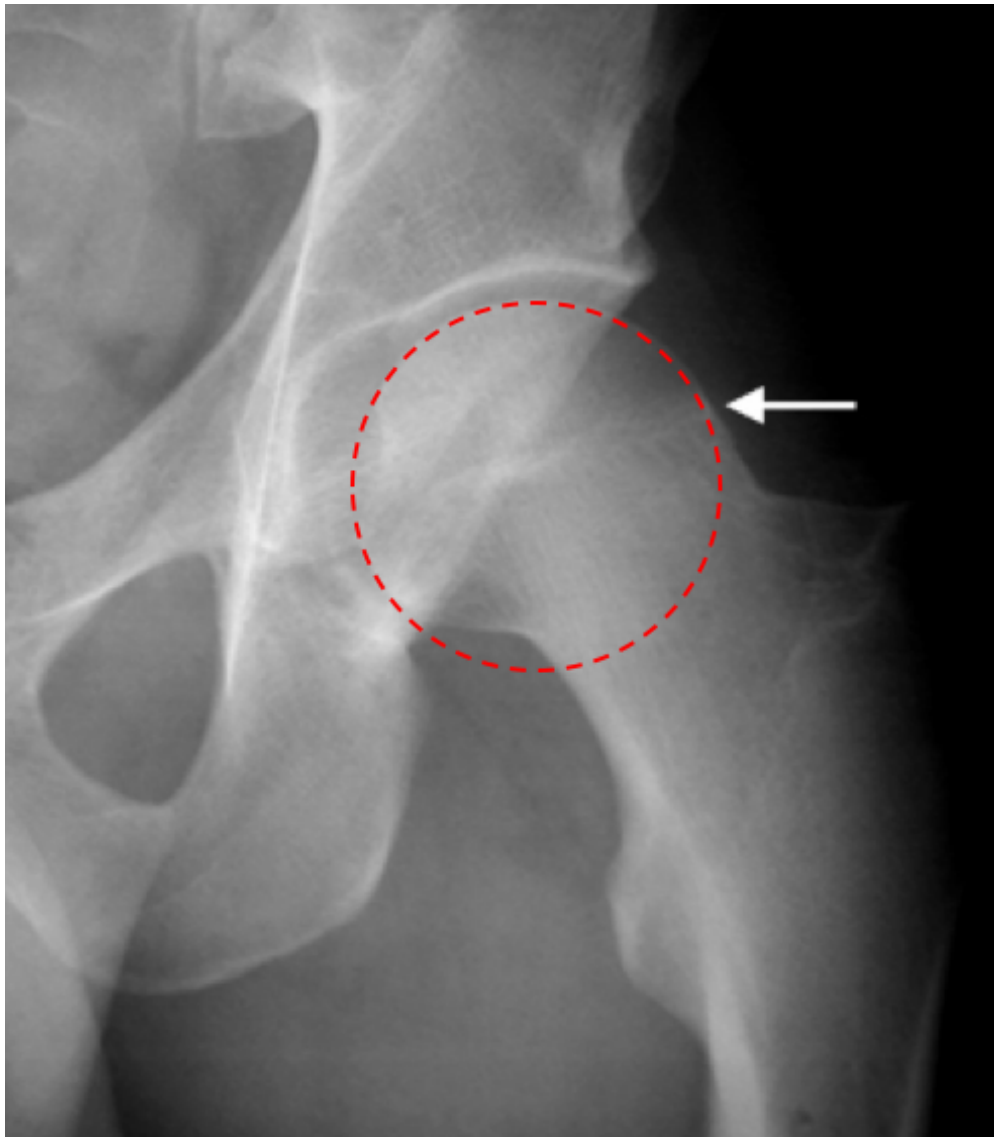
A radiographic image showing a point of impingement. The red circle is included to show where the asphericity of the femoral head connecting to the femoral neck occurs [102]
